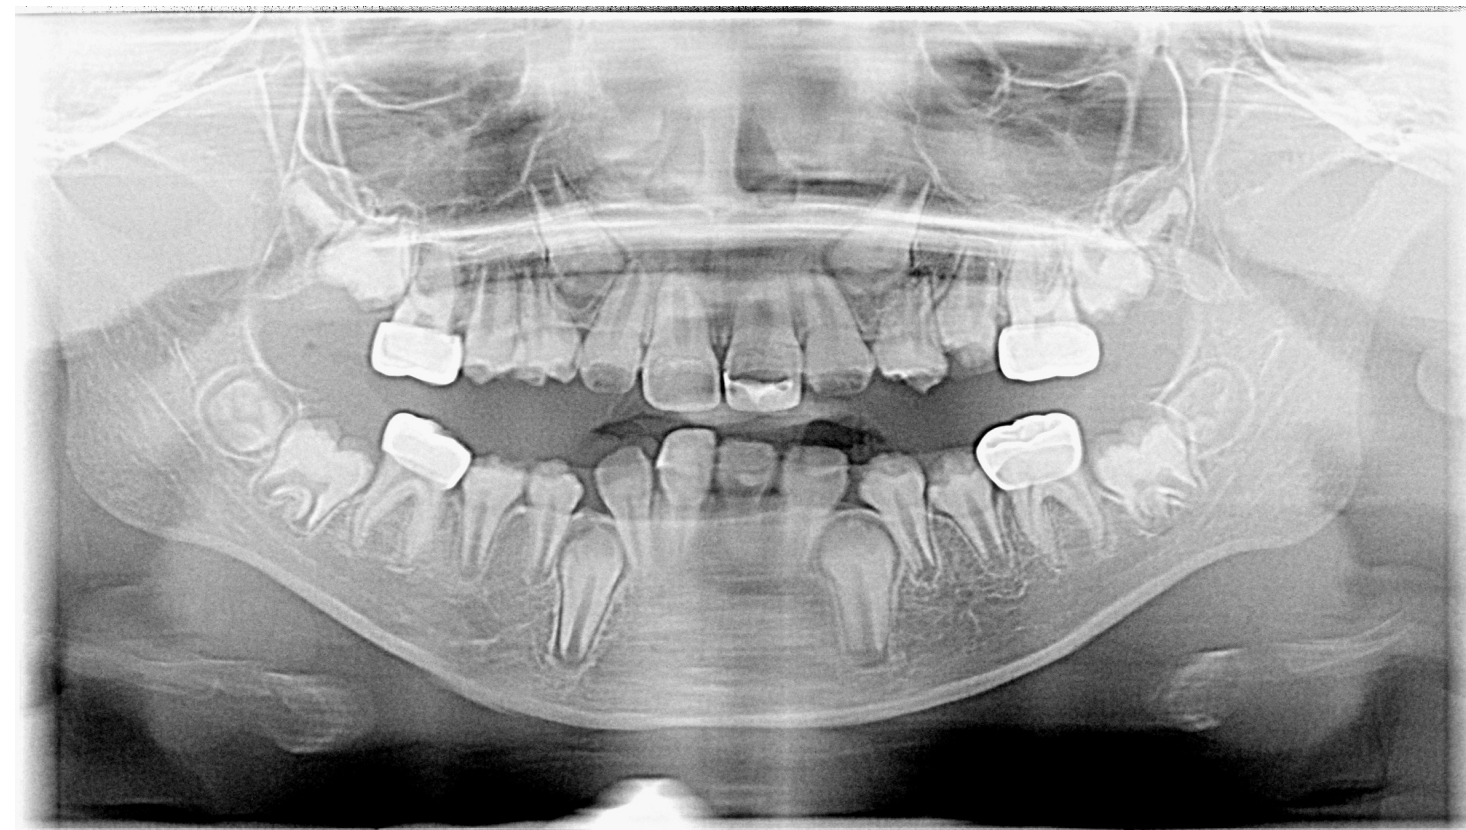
Panoramic Radiograph
